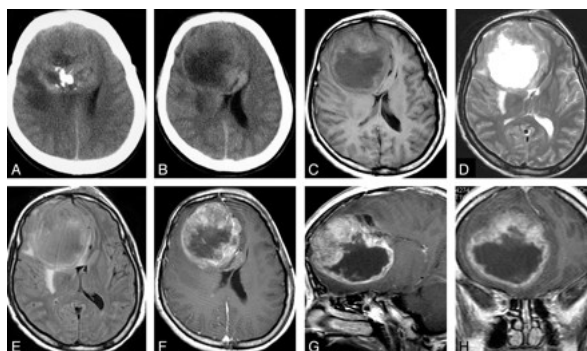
A. a T1-weighted MR image, shows a necrotic area. This necrotic area is hypointense, and the solid area is isointense. D. T2-weighted MR image, shows a hyperintense cystic area and an isointense solid area. E. FLAIR MR image, demonstrates isointense and hyperintense signal intensity with mild peritumoral edema.
